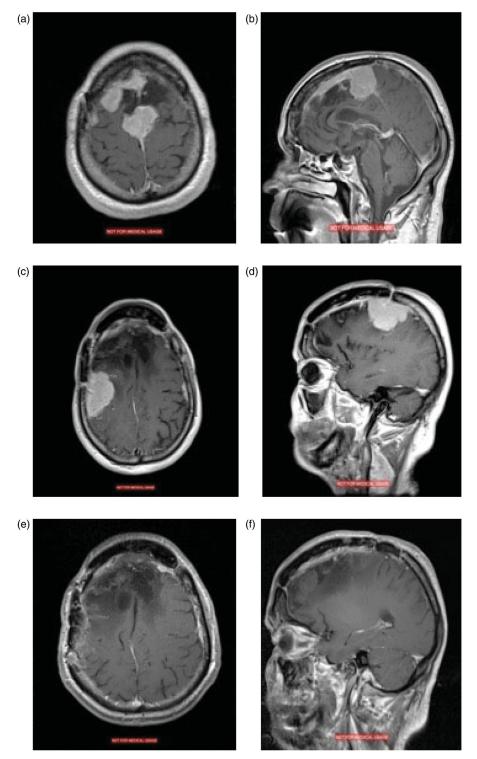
Post-contrast MRI of a patient who underwent resection of a 3-cm anterior parasagittal meningioma and stereotactic radiosurgery in 2006. (a, b) MRI at 3 years: diffuse recurrence involving both the falx and the convexity treated by gross total resection; (c, d) MRI in 2014: second recurrence involving the right temporoparietal region and the middle parasagittal region; (e, f) MRI in 2015: complete tumor resection with diffuse linear dural enhancement.
